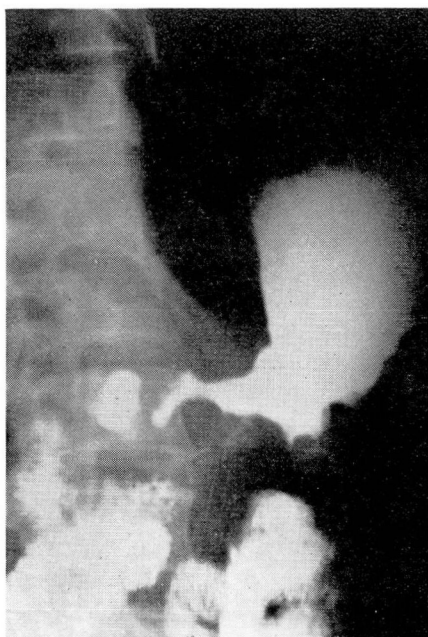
Roentgenogram showing extensive infiltrating carcinoma of the stomach requiring total gastrectomy.
